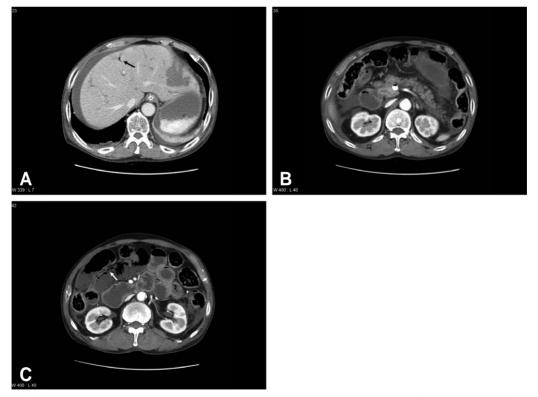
(A) Portal vein gas (black arrow) and perihepatic fluid collection. (B) Acute pancreatitis. (C) Pneumatosis cystoides intestinalis (white arrow). CT scan of the abdomen with intravenous contrast shows (A) gas in the portal vein (black arrow) and perihepatic fluid collection, (B) acute pancreatitis with peripancreatic fluid collection and gas within the superior mesenteric vein, and (C) pneumatosis cystoides intestinalis (white arrow), poor enhancement and fluid-filled dilatation of the small bowel loops.
